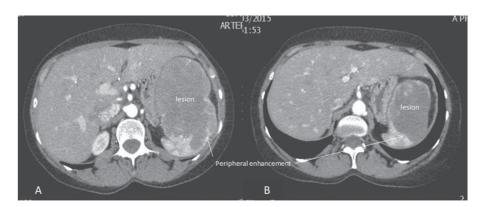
A CT scan (axial view, arterial phase) of the abdomen performed at presentation showing an enlarged spleen with a giant upper splenic pole lesion ( $11 \times 8.0 \times 7.7$  cm). The lesion exhibited peripheral enhancement in the arterial phase (Panel A) and peripheral to central enhancement progression in the venous and delayed phases. Panel B shows the CT scan (axial view, arterial phase) performed 1 year after partial splenic embolization showing interval regression in the lesion size (now  $8.3 \times 5.8 \times 5.3$  cm vs. pre-embolization size  $11.0 \times 8.0 \times 7.7$  cm).
